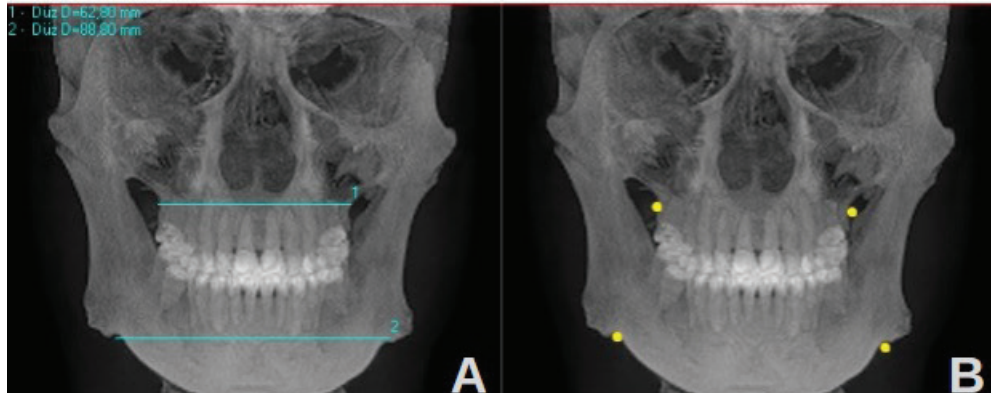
A-Image of mandibular and maxillary width measurement, B-Image of mandibular and maxillary reference points an antero-posterior radiograph of the patient.
